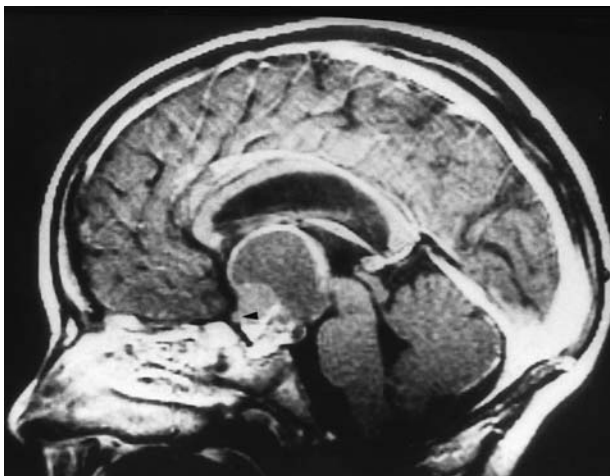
Midsagittal MRI showing a cystic craniopharyngioma in the suprasellar and third-ventricle location. Note that the optic chiasm (*arrowhead*) is depressed (pre-fixed chiasm).
